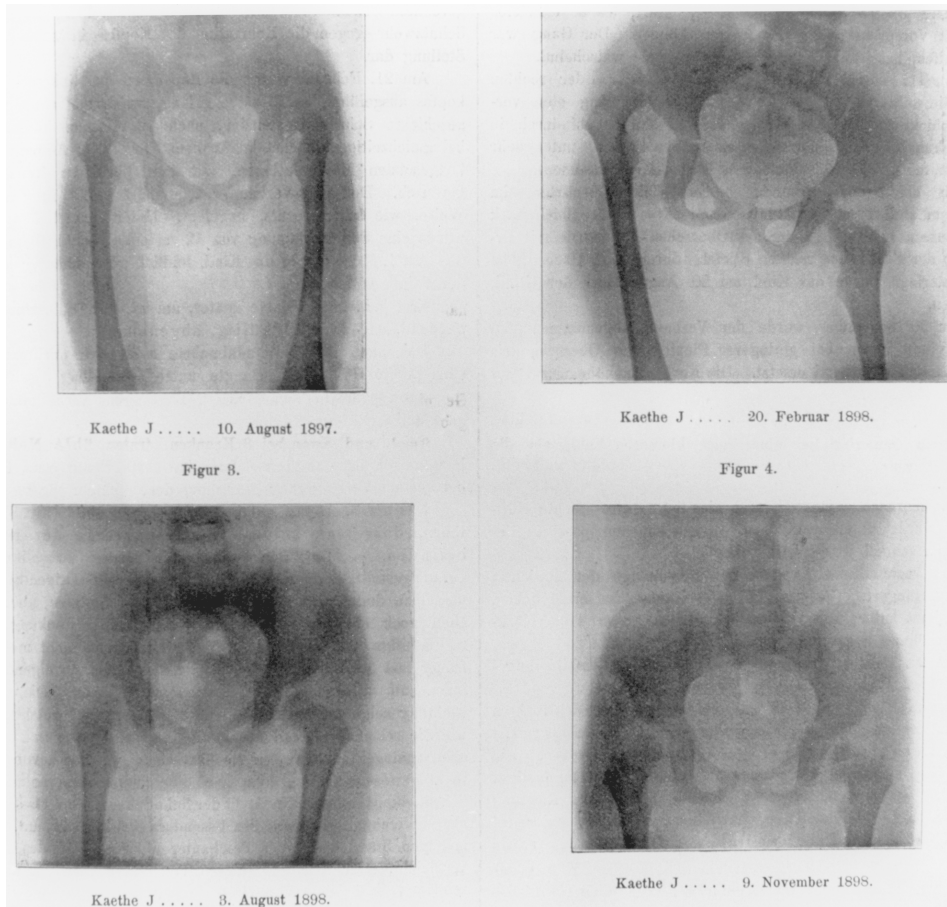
This image sequence shows (compare Figure 2) how X-rays transformed the doctor's understanding of the diagnosis and treatment of a malformed hip. The functional fault and cure, assessed by the stance and gait of the whole patient, have been replaced by the anatomical diagnosis and cure assessed through disembodied X-ray shadows. One should keep in mind Wolff's comment that these images had lost "beauty and sharpness" compared with the original plates. (Julius Wolff, "Über die unblutige Einrenkung der angeborenen Hüftgelenksverrenkung," *Berliner Klinische Wochenschrift*, 1899, 36:383. Reproduced by kind permission of the Royal Society of Medicine, London.)
